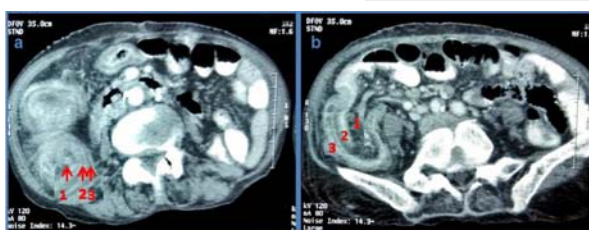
(a,b) — CT scan images showing Triple Circle Sign suggestive of Compound Intussusception
